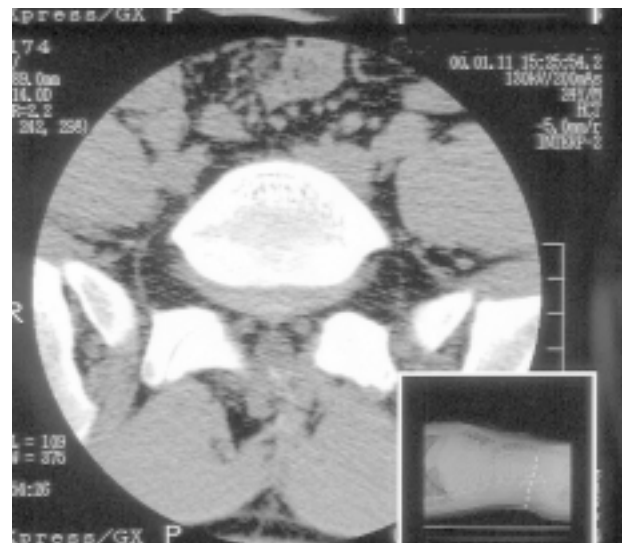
Double vertebral body outline symptom in CT findings
